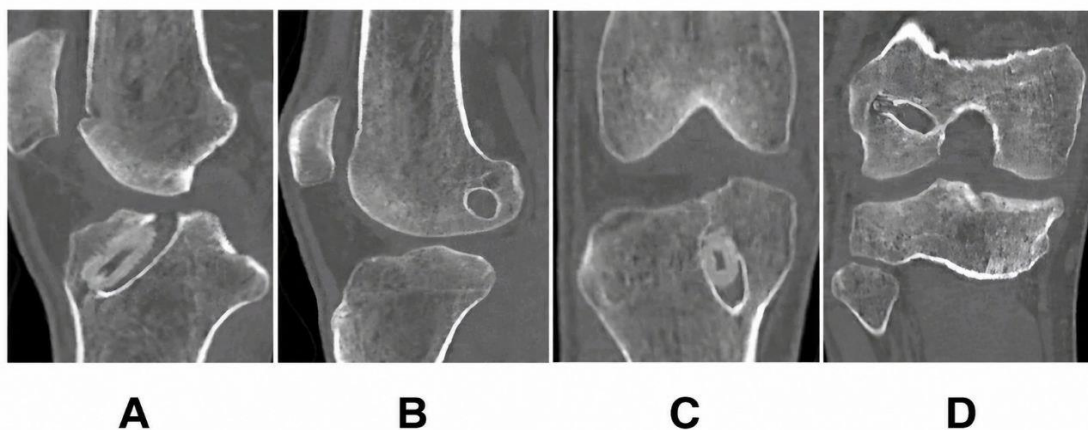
Preoperative computed tomography (CT) evaluation of the previous ACL reconstruction tunnels. A) Sagittal CT image demonstrating the previous tibial tunnel; B) Sagittal CT image demonstrating the previous femoral tunnel; C) Coronal CT image demonstrating the previous tibial tunnel; D) Coronal CT image demonstrating the previous femoral tunnel
